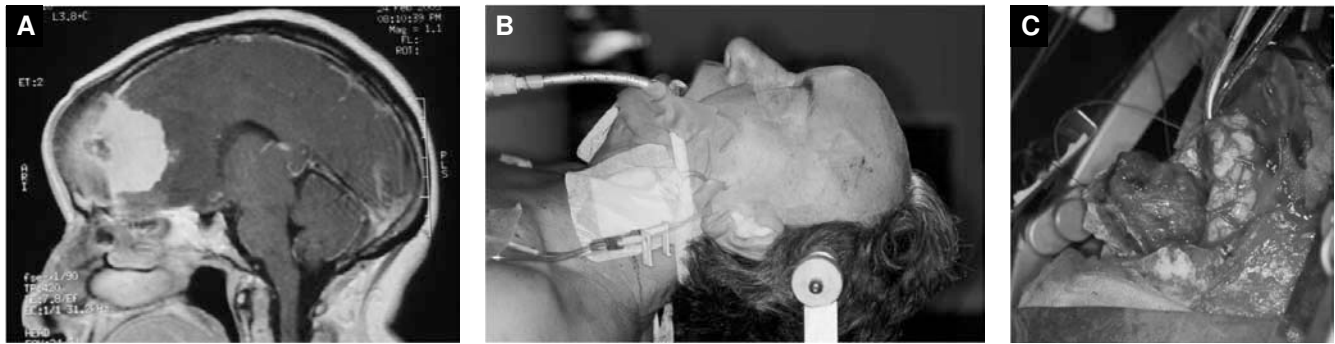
A. Sagittal magnetic resonance image of a large frontal meningioma. B and C. Exposure of the meningioma.
